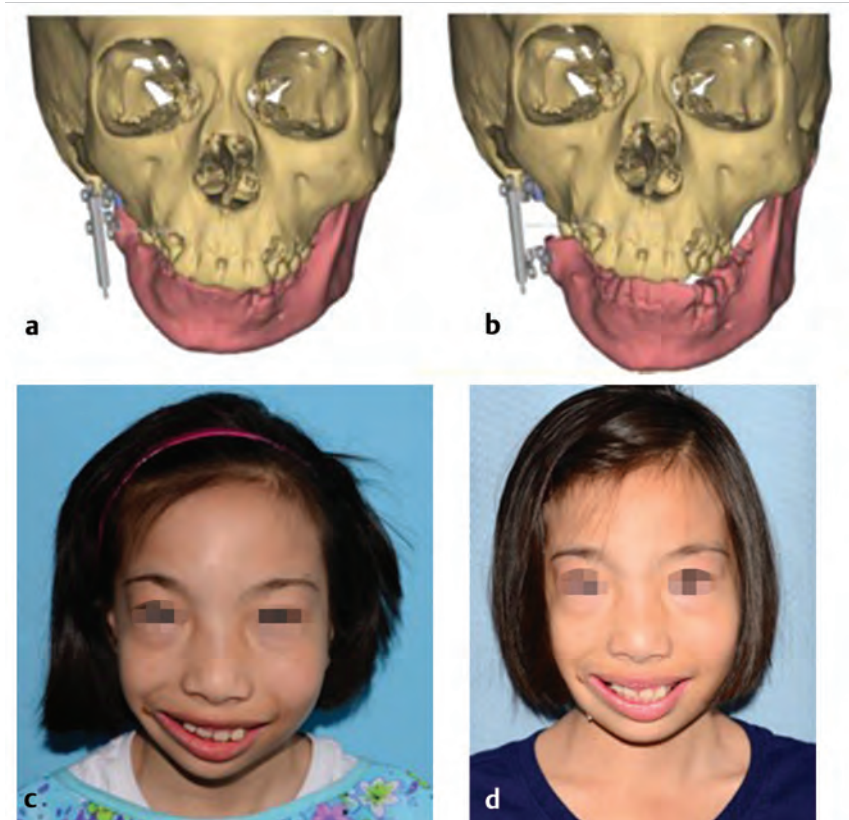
Mandibular distraction osteogenesis CT planning (a,b) and pre- and postoperative photographs (c,d) in a patient with hemifacial microsomia.
